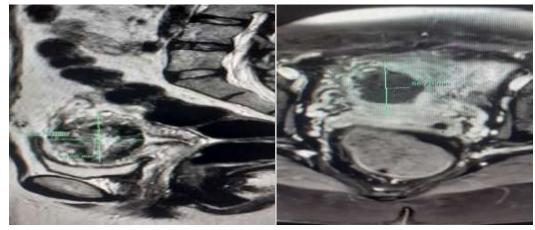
Transverse and longitudinal sections for pelvic MRI of caesarean section scar ectopic pregnancy, Tripoli, Libya, 2022.
